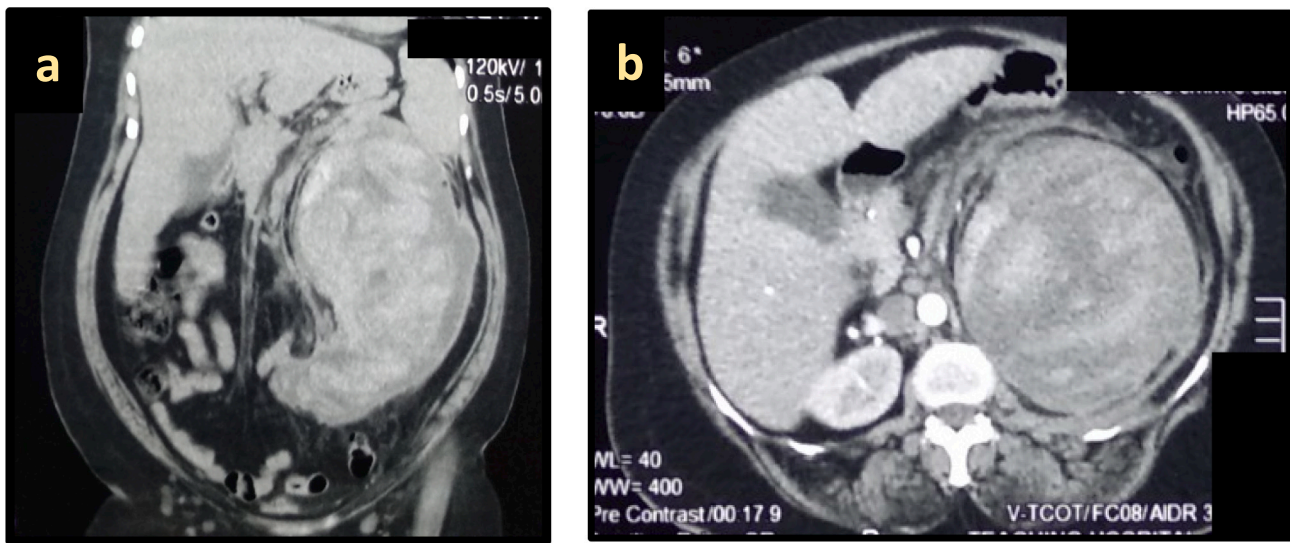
a: Coronal section CT abdomen shows the left side large intrarenal and perirenal hematoma with vertical extension up to the pelvic brim. b: The axial section reveals large renal hematoma (intrarenal and perinephric hematoma) 20 × 27 cm with distorted renal parenchyma, and it is confined to the Gerotas fascia.
